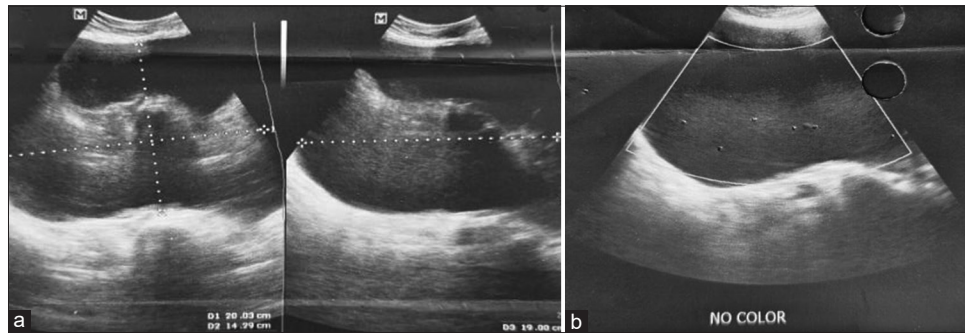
Ultrasound findings of the ovarian mass: (a) The transverse and anteroposterior views of the pelvoabdominal mass described as predominantly solid with smooth external surface; (b) Color flow mapping was absent (Color Score of 1)
